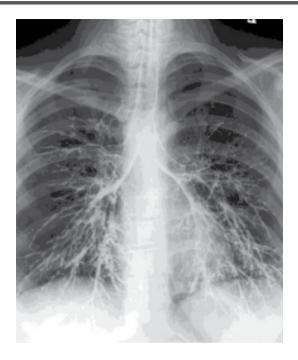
X-ray contrast bronchogram
